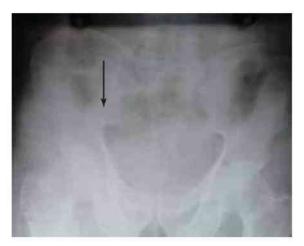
X-ray of the anteroposterior view of the pelvis showing tuberculosis of the right sacroiliac joint with articular erosion and reduced joint space.
